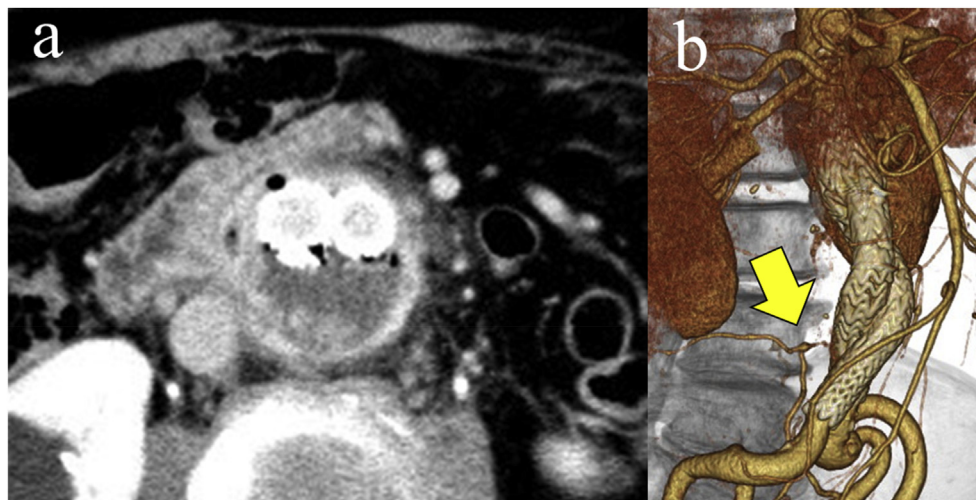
Delayed enhanced CT on re-admission (A) demonstrated type II endoleak from third lumbar artery (A). 3D reconstruction (B) (yellow arrows show third lumbar artery).
